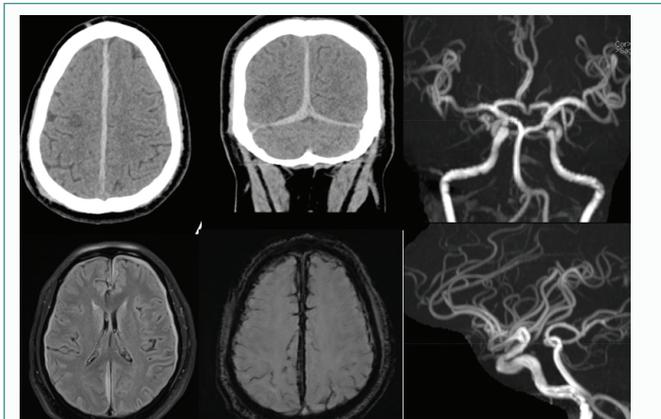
A and B) CT scan brain plain axial and coronal reconstruction image showing acute hyperdense interhemispheric and transtentorial subdural haemorrhage. C) T2FLAIR axial image showing hyperintense collection in interhemispheric and b/l cerebral convexities. D) SWI showing susceptibility artefact in interhemispheric and convexity region s/o haemorrhage. E and F) TOF Angiogram AP and lateral view showing no obvious vascular abnormality.
